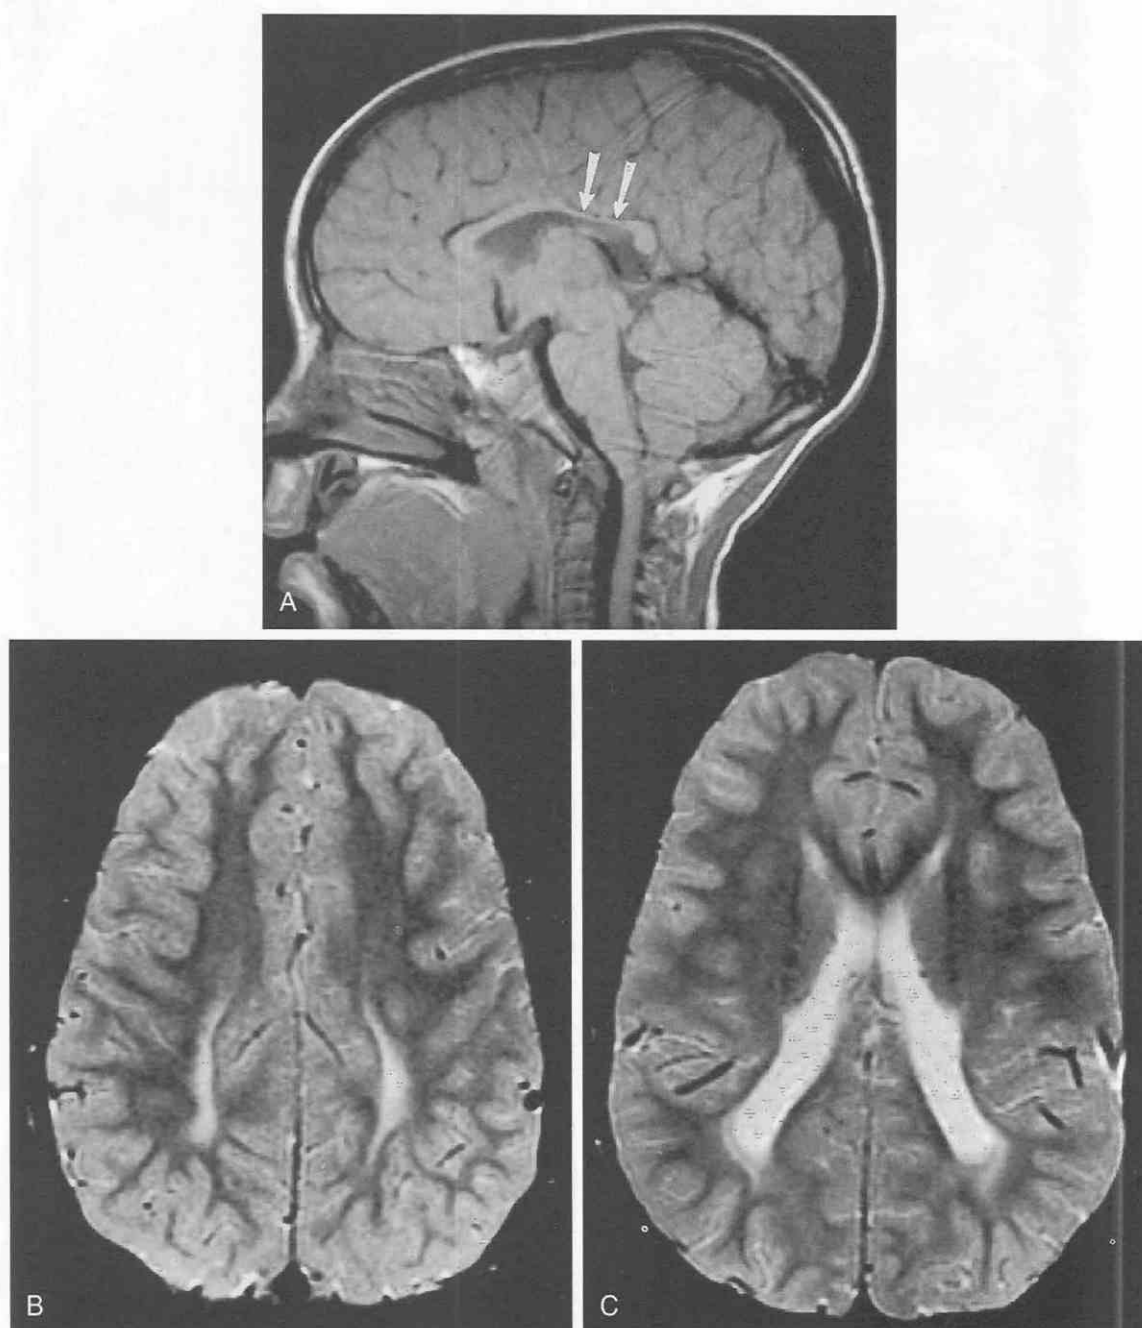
End-stage periventricular leukomalacia. *A*, T1-weighted sagittal image shows focal thinning of the posterior portion of the body of the corpus callosum (arrows). *B* and *C*, T2-weighted axial images show dilation of the atria of the lateral ventricles and increased signal in the deep periventricular white matter. There are a number of causes of periventricular leukomalacia, one of which is hypoxic-ischemic encephalopathy.
